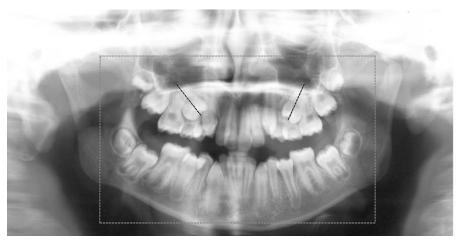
An 11-year 3-month old girl exhibiting mesially inclined upper second premolars on the panoramic radiograph, but orthograde premolars on the lateral headfilm. The section marked on the panoramic radiograph was used in the e-mail survey.
